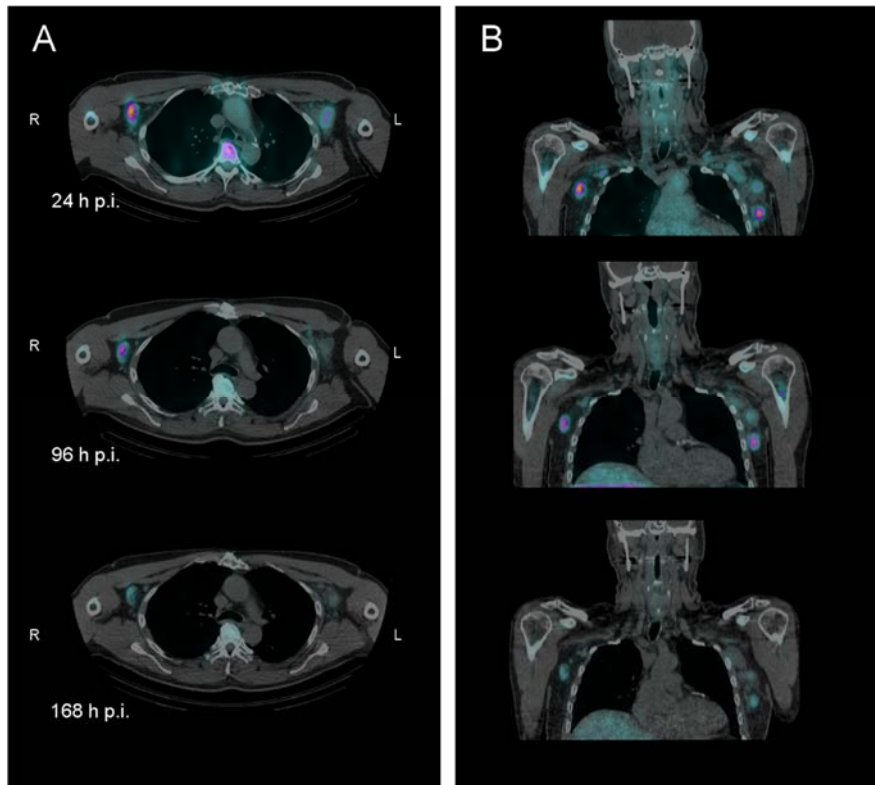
Axial (A) and coronal (B) SPECT/CT-fused images of patient 13 at three time points after administration of ^{177}Lu -lilotomab satetraxetan. Tumor 13b can be seen in the left axilla, and 13c in the right. The tumor dosimetry was based on multiple SPECT/CT-scans.
